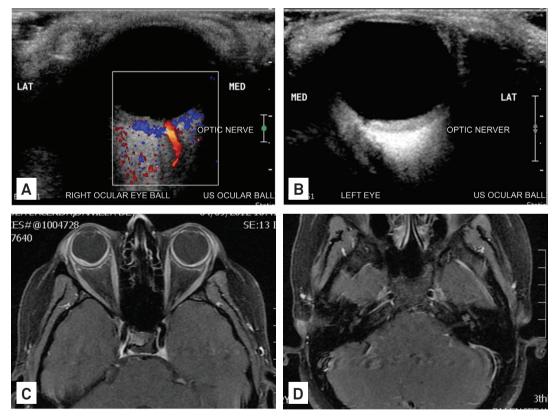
(A) and (B) Ultrasound (USG) of the eyeballs: increased vascularization and thickening of the posterior choroidal eyeballs. (C) and (D) Magnetic resonance imaging (MRI) of the brain and orbits. (C) Thickening and impregnation by gadolinium anomaly in the posterior aspect of the eyeballs, suggestive of uveitis. (D) Impregnation anomalous bilateral membranous labyrinth, suggestive of labyrinthitis.
